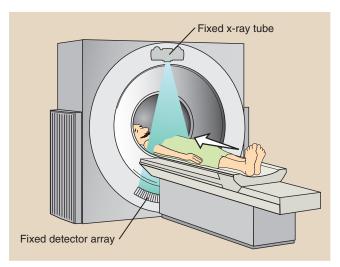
A scanned projection radiograph is obtained in computed tomography by maintaining the energized x-ray tube–detector array fixed while the patient is translated through the gantry.
